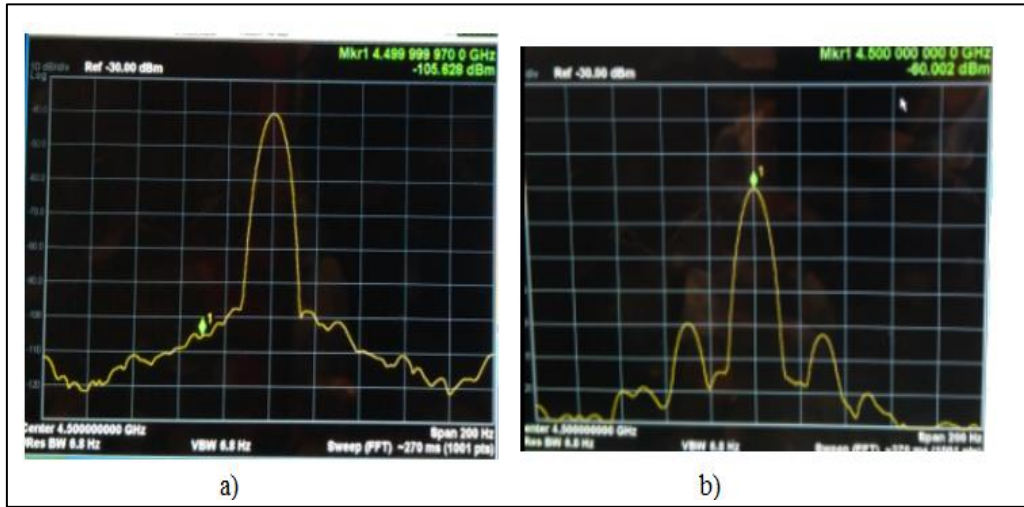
The spectrum of the received signal at the spectrum analyzer a) without MSC circuit and b) with MSC circuit. With the utilization of MSC circuit, the main signal is suppressed by approximately 20 dB and in the spectrum analyzer the Doppler signal become visible.
